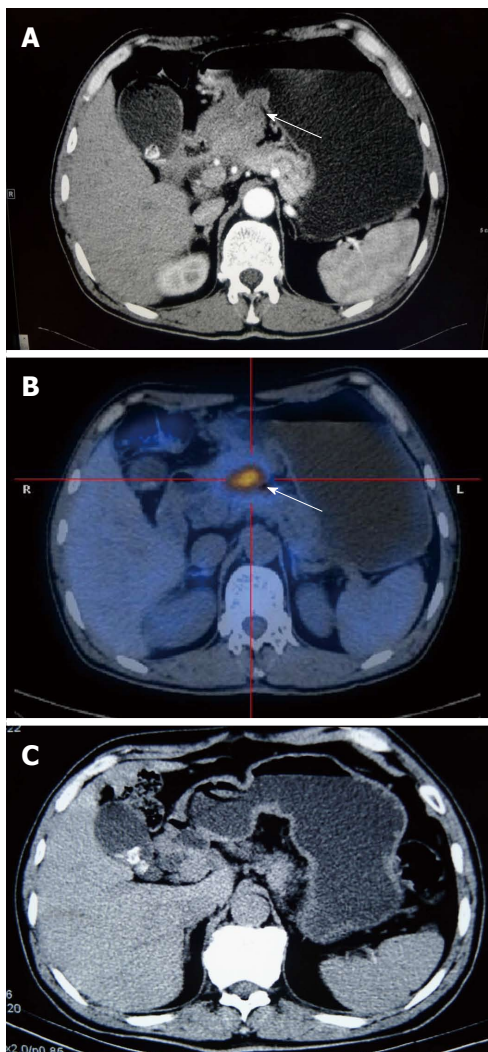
Computed tomography/positron emission tomography-computer tomography imaging changes of patient No. 2. A: A computed tomography (CT) scan on admission showed that the gastric wall at the antrum was clearly thickened and enhanced (white arrow) in the arterial phase. Several lymph nodes could also be observed, the biggest one being approximately 3.9 cm in diameter; B: A positron emission tomography-computer tomography on admission showed a high FDG (fluorodeoxyglucose) uptake mass located at the interval between the antrum and pancreas (white arrow). The maximum standardized uptake value (SUV max) was 11.7, and the retention index was 21.8%; C: A CT scan obtained 1 mo after discharge identified the spontaneous regression of the tumor.
